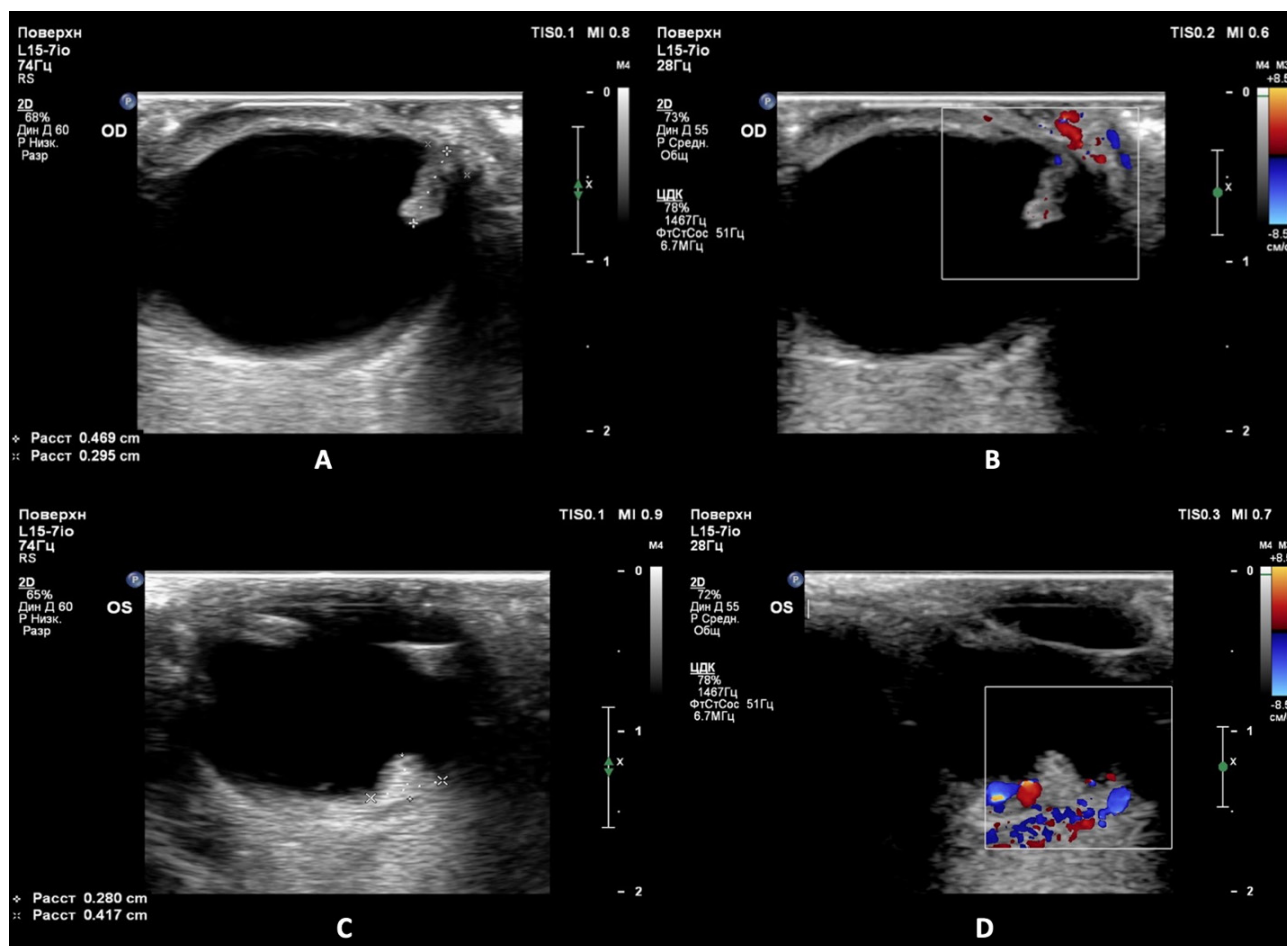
A – B-mode ultrasonography of the rabbit's right eye (non-pigmented model): in the upper part of the image, a modeled intraocular mass lesion without pigment is visible, measuring 4.6 mm in height and up to 2.9 mm in base diameter. B – CDI mode of the same eye: color flow signals within the lesion projection. C – B-mode ultrasonography of the rabbit's left eye (pigmented model): in the lower part of the image, a pigmented intraocular mass lesion is visible, measuring up to 2.8 mm in height and 4.1 mm in base diameter. D – CDI mode of the left eye: color flow detected along the peripheral margins of the alloplant
